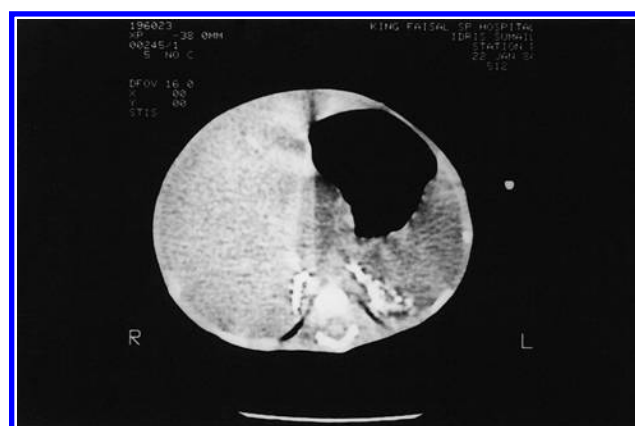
In this view, the computed tomography scan clearly shows both adrenals to be densely calcified.
